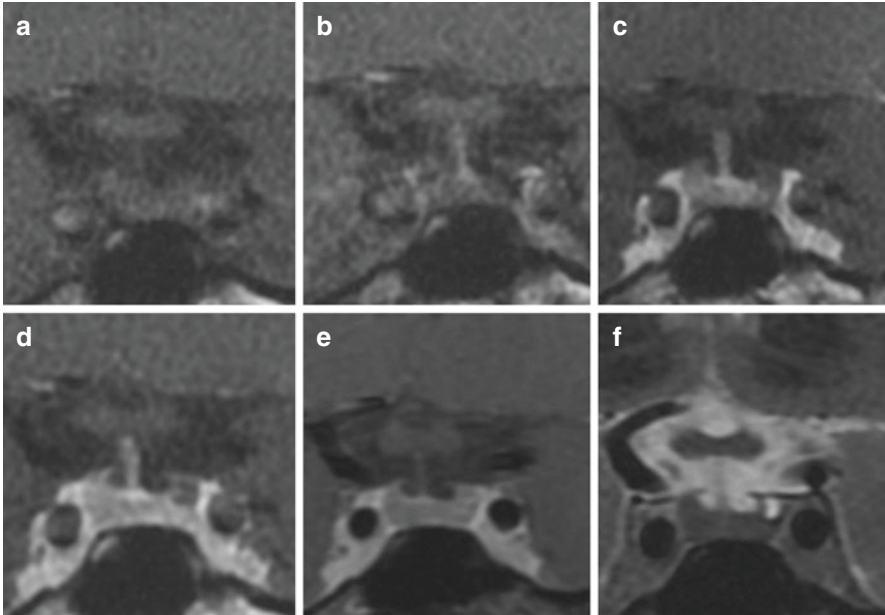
MRI appearance of a pituitary microadenoma. (a–d) Dynamic post-contrast T1-weighted coronal imaging shows progressive enhancement of the pituitary with relative hypoenhancement of a small nodule in the left aspect of the pituitary, characteristic of a pituitary adenoma. (e) There is loss of visualization of the left-sided pituitary adenoma on delayed post-contrast T1-weighted coronal imaging. (f) T2-weighted coronal imaging shows associated T2 hyperintense signal
